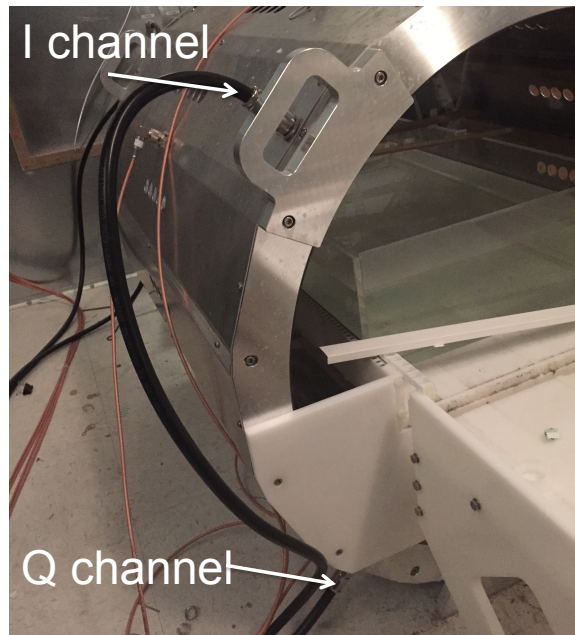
The I/Q feed of the MRI RF coil.
